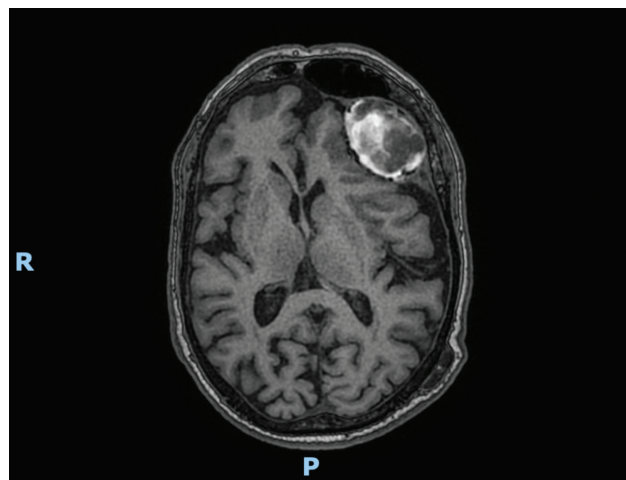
T1-weighted non-contrast magnetic resonance imaging (MRI) scans of the brain in the axial plane, showing the same collection as ►Fig. 1. Abbreviations: R, right; P, posterior.
